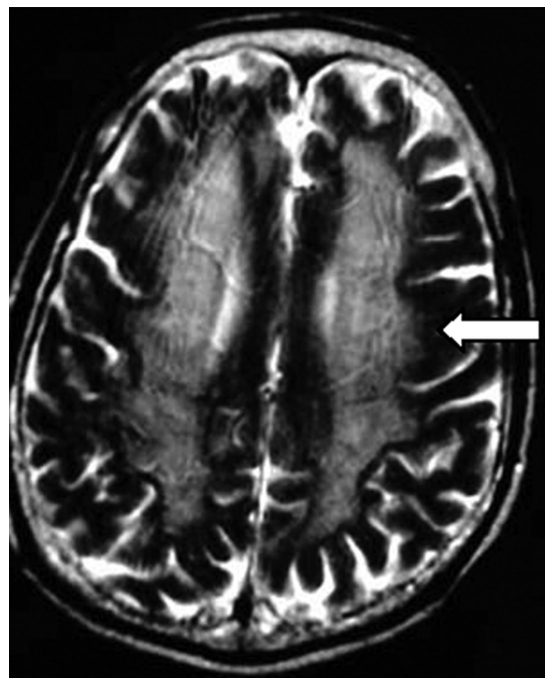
Axial T2-weighted image through the cerebral hemispheres shows confluent high signal hyperintensity in the subcortical white matter (arrow).
